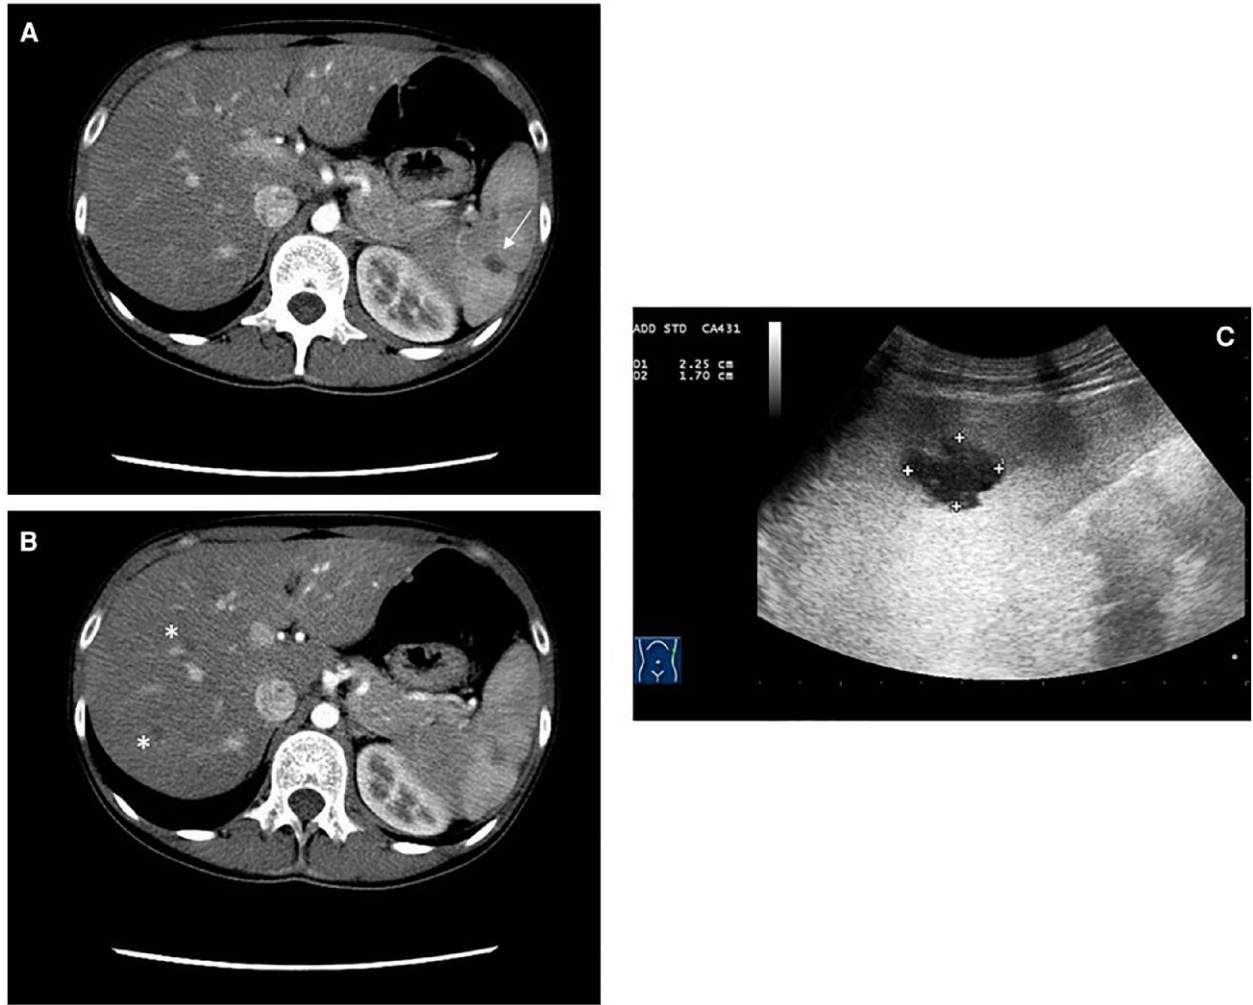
A, Axial computed tomographic (CT) scan showing abscess of the spleen (*arrow*). B, Axial CT scan showing abscesses of the liver (*asterisks*). C, Ultrasonography of the spleen, performed with convex probe, showing irregular hypoechoic nonvascular area compatible with abscess.
